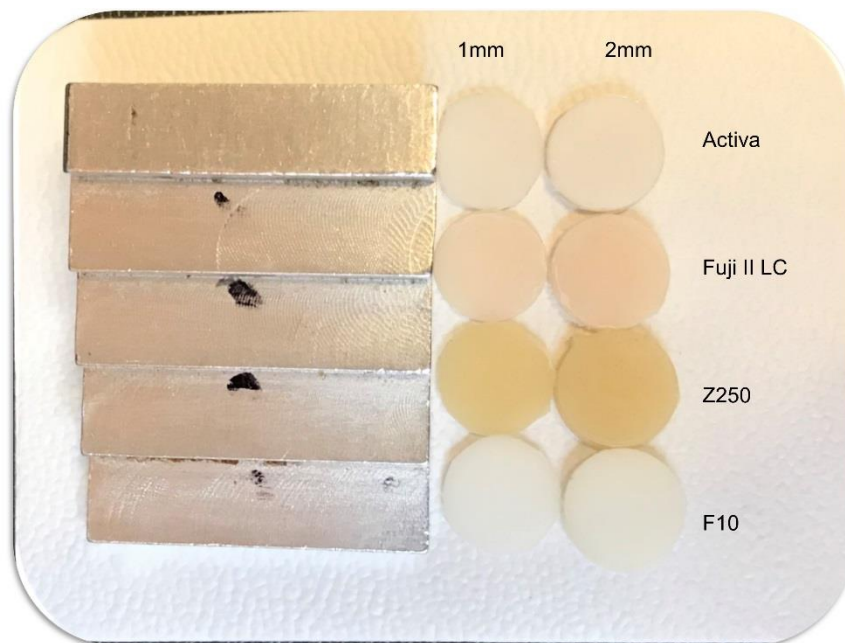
Radio-opacity test. X-ray images of two thicknesses of different materials were taken and analysed in comparison to the aluminium step-wedge.
